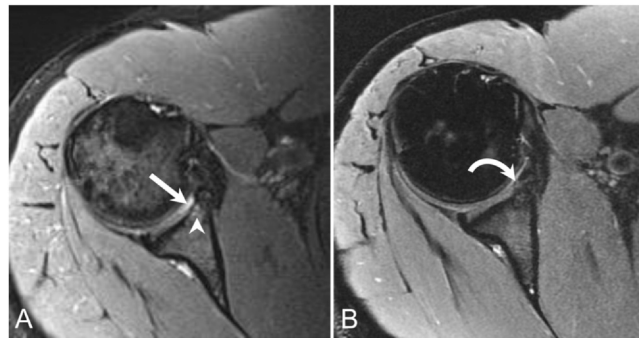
Professional hockey player with chronic shoulder pain. Axial PD FS MR image (A) of the shoulder demonstrates focal full-thickness cartilage loss at the anteroinferior glenoid (arrow) with underlying subchondral edema/cystic changes (arrowhead). Axial PD FS MR image (B) from a follow-up MRI performed 1 year later, several months after intra-articular stem cell injection, demonstrates interval cartilage regeneration at the anteroinferior glenoid (curved arrow) with improvement of the accompanying subchondral bone marrow changes. FS, fat saturation; MR, magnetic resonance; MRI, magnetic resonance imaging; PD, proton density.
